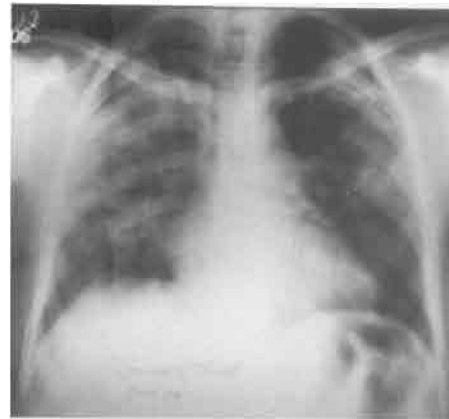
X-Ray Chest: Increase of Lung Lesions
